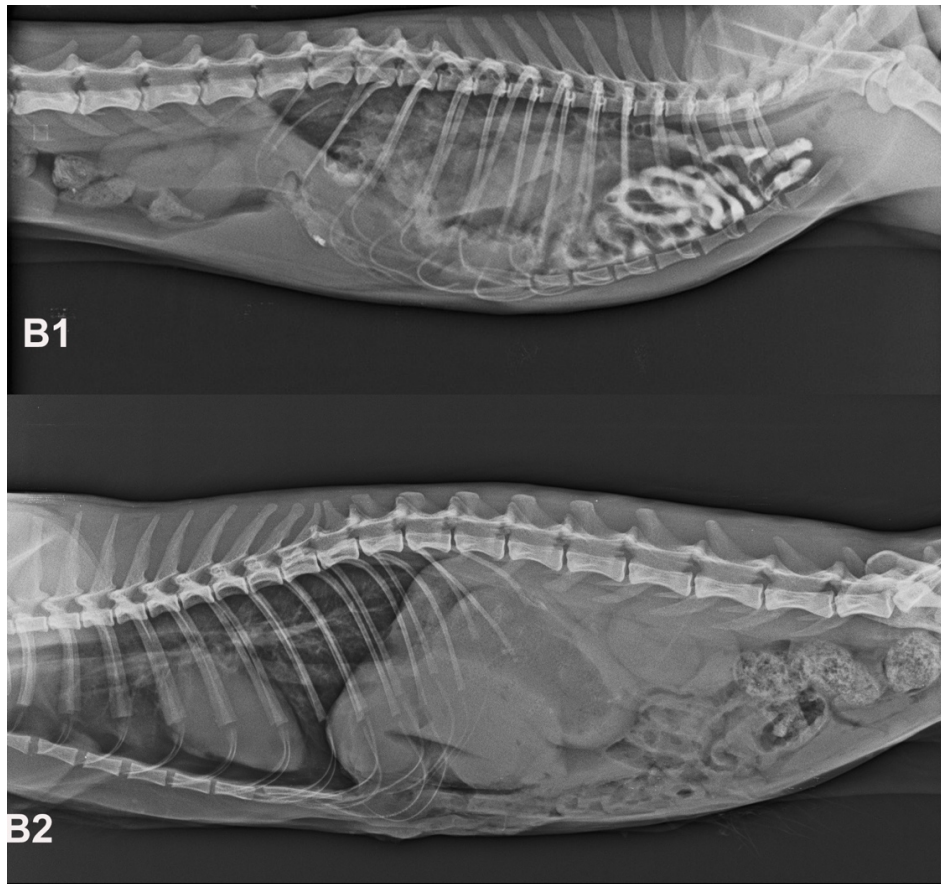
B1 View of the intestinal segment within the thorax using contrast radiography. B2 Post-operative image of the case.
